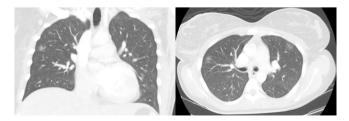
CT of the chest with intravenous contrast showing small ground-glass nodular opacities within the upper lobes. No pleural collections, mediastinal or hilar lymph node enlargement were noted.
